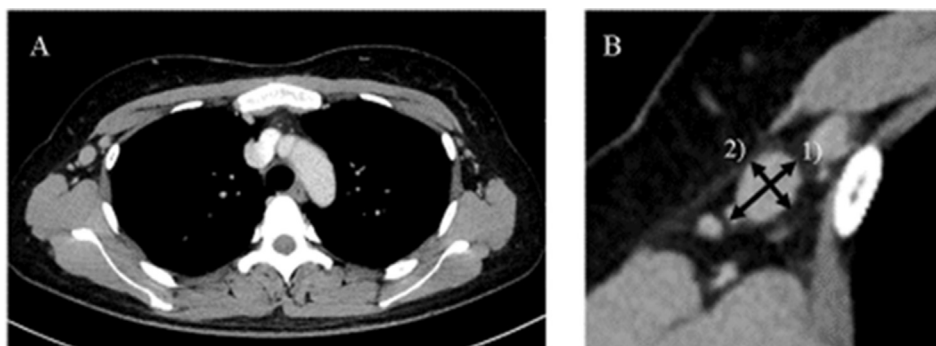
The shape of the lymph nodes on computed tomography (A). The long-axis diameter (B-1) and short-axis diameter (B-2) of the lymph node.
